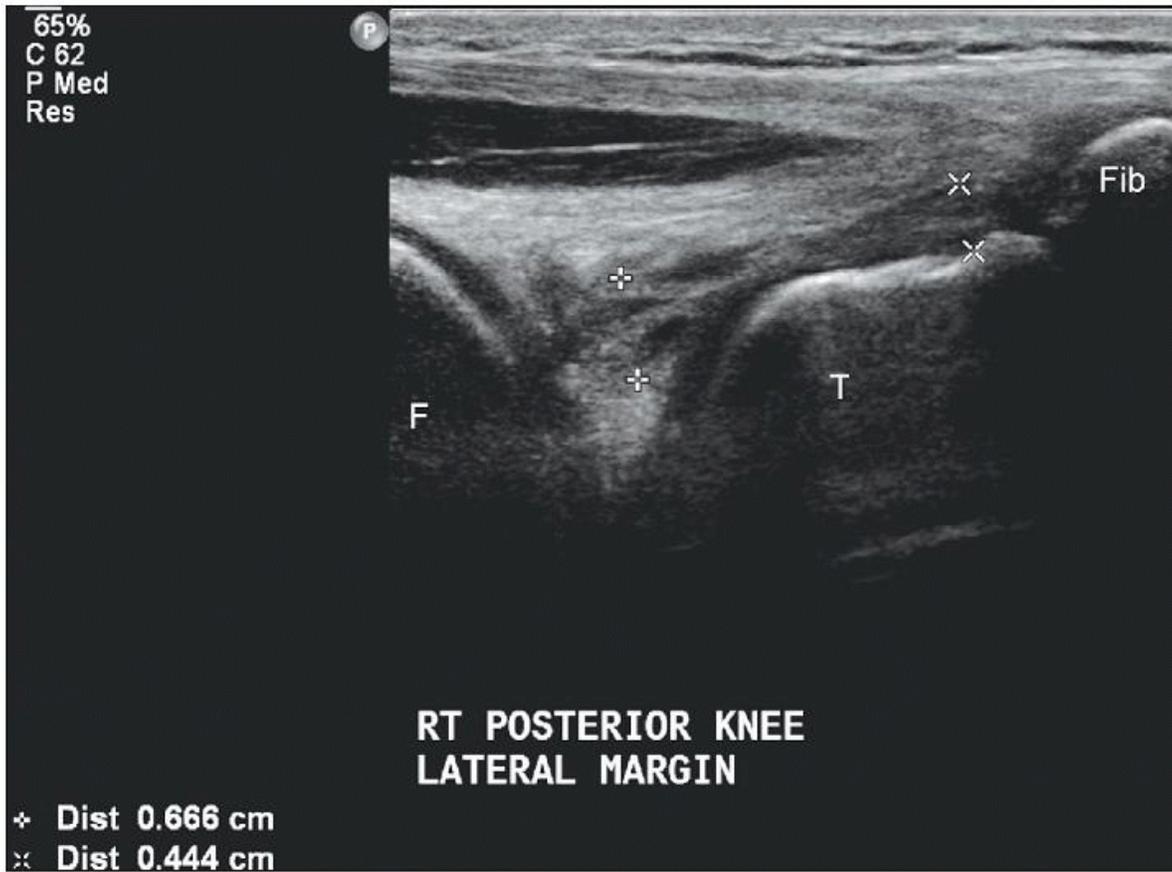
Longitudinal oblique ultrasound image of a scarred arcuate ligament (caliper marks). F, femur; T, tibia; Fib, fibula.
